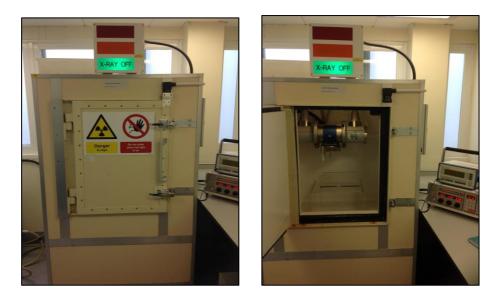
The AGO X-Ray machine and its chamber
